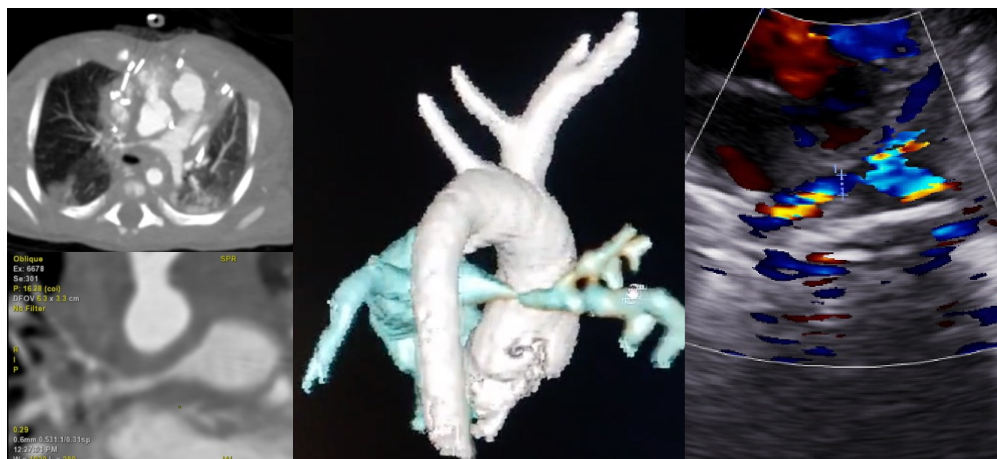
Tomographic image of critical RPB stenosis (left), 3D reconstruction (center) of the lesion and pulmonary tree in blue and aorta artery in white, in posterior view. Transthoracic echocardiogram (right).
